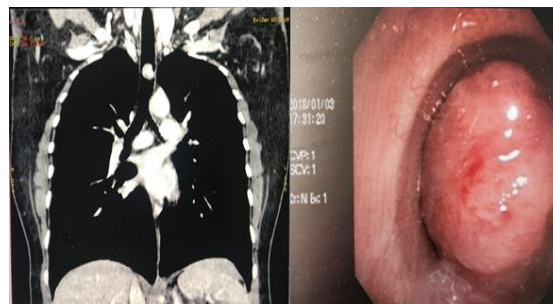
(i) coronal view of CT chest showing tracheal tumor obliterating >95% of its lumen. Fig. (ii) bronchoscopic view of tracheal tumor
